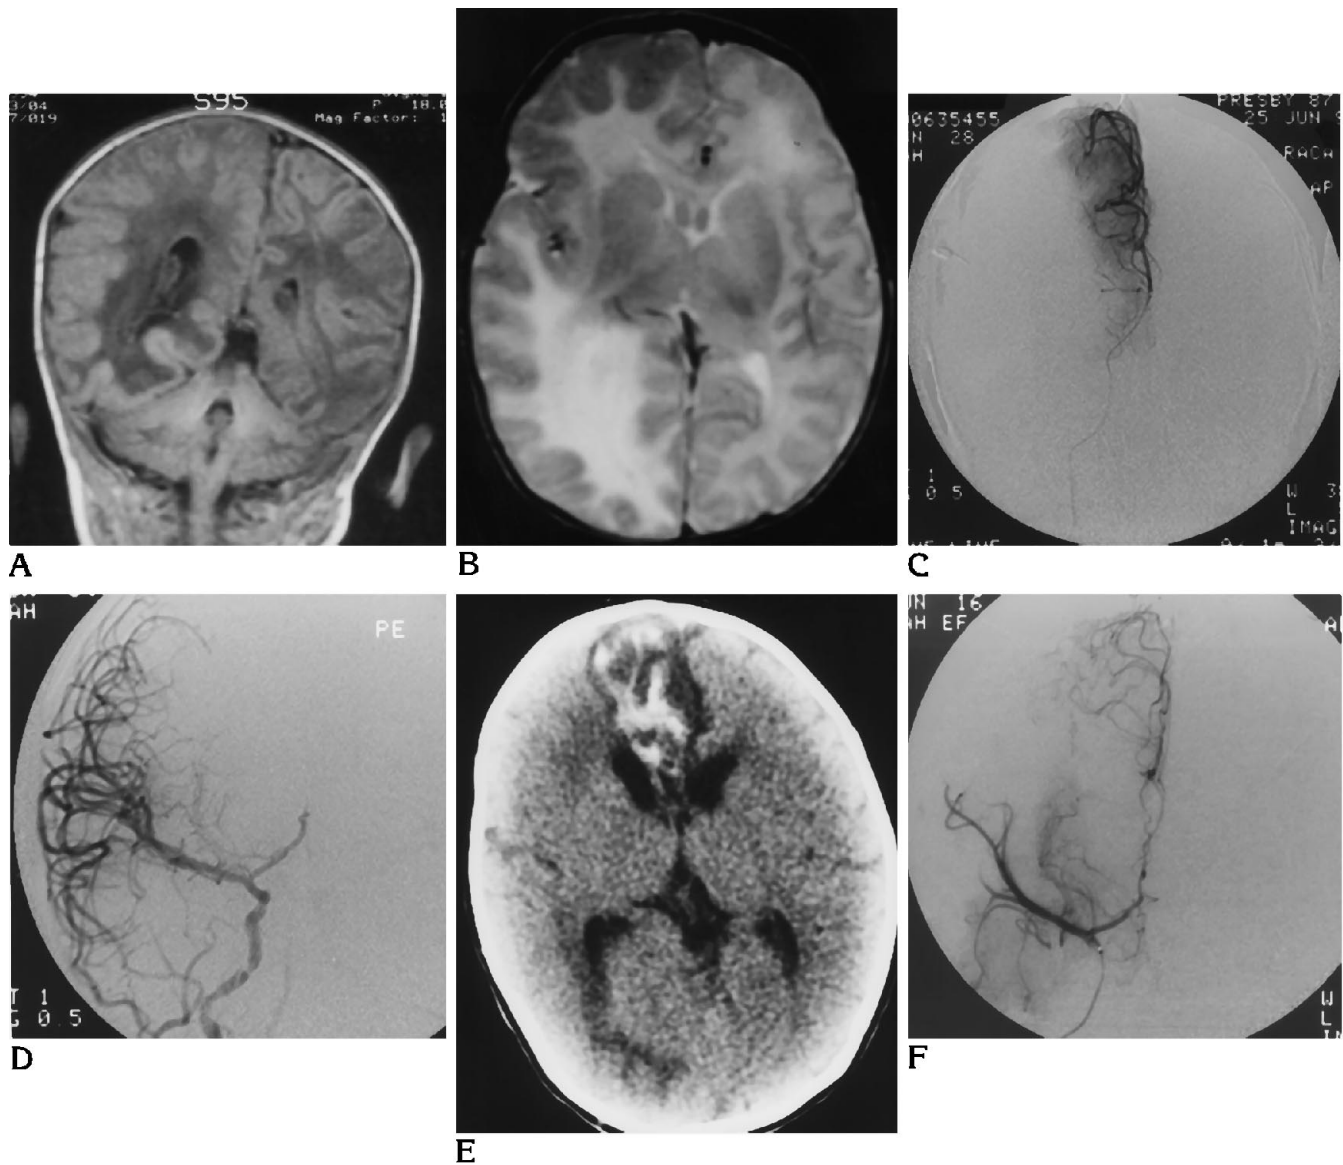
A, Coronal MR image with short repetition and echo times shows enlargement of the right hemisphere with right ventriculomegaly.
